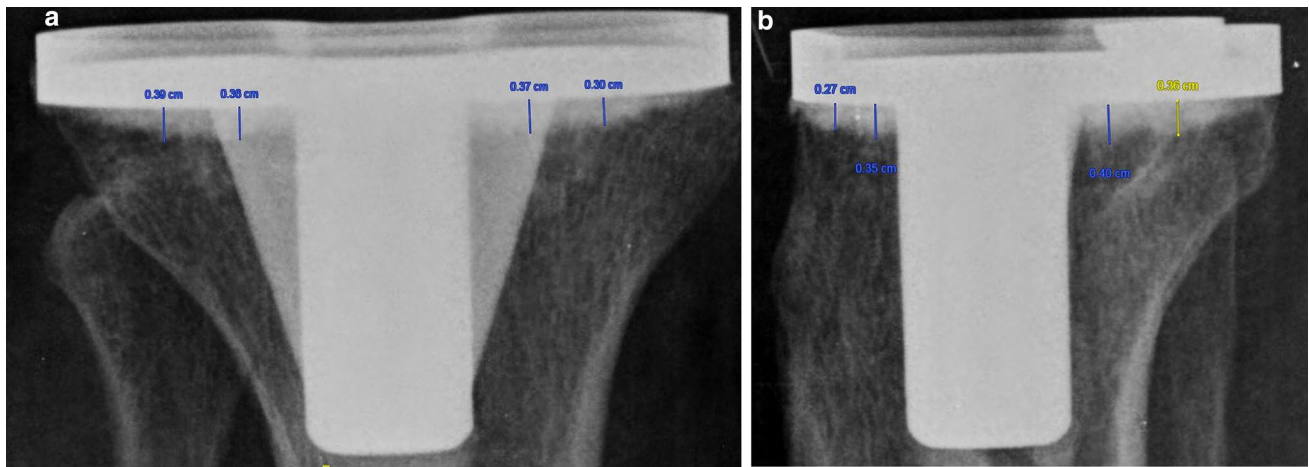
a, b Radiographic measurement of the cement bone intrusion in the tibia in four areas in the AP view (two medial and two lateral to the keel) and in four areas in the lateral view (two anterior and two posterior to the keel)
